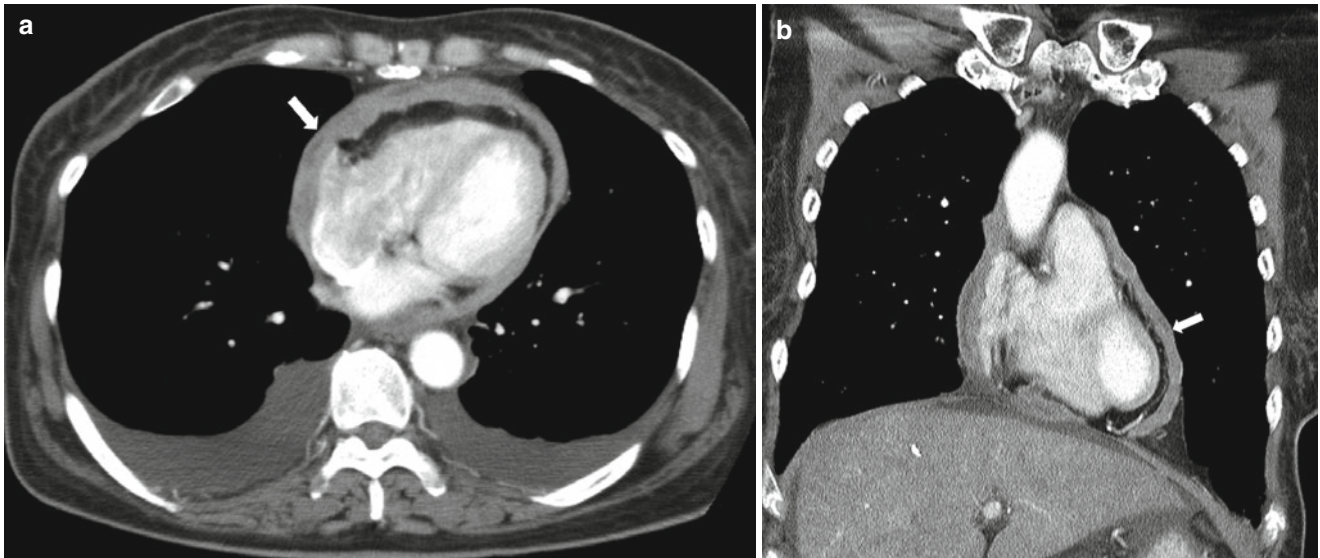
Pericardial mesothelioma. (a, b) Axial and coronal images of chest CT show diffuse nodular enhancing pericardial thickening (arrows) and small amount of bilateral pleural effusion
